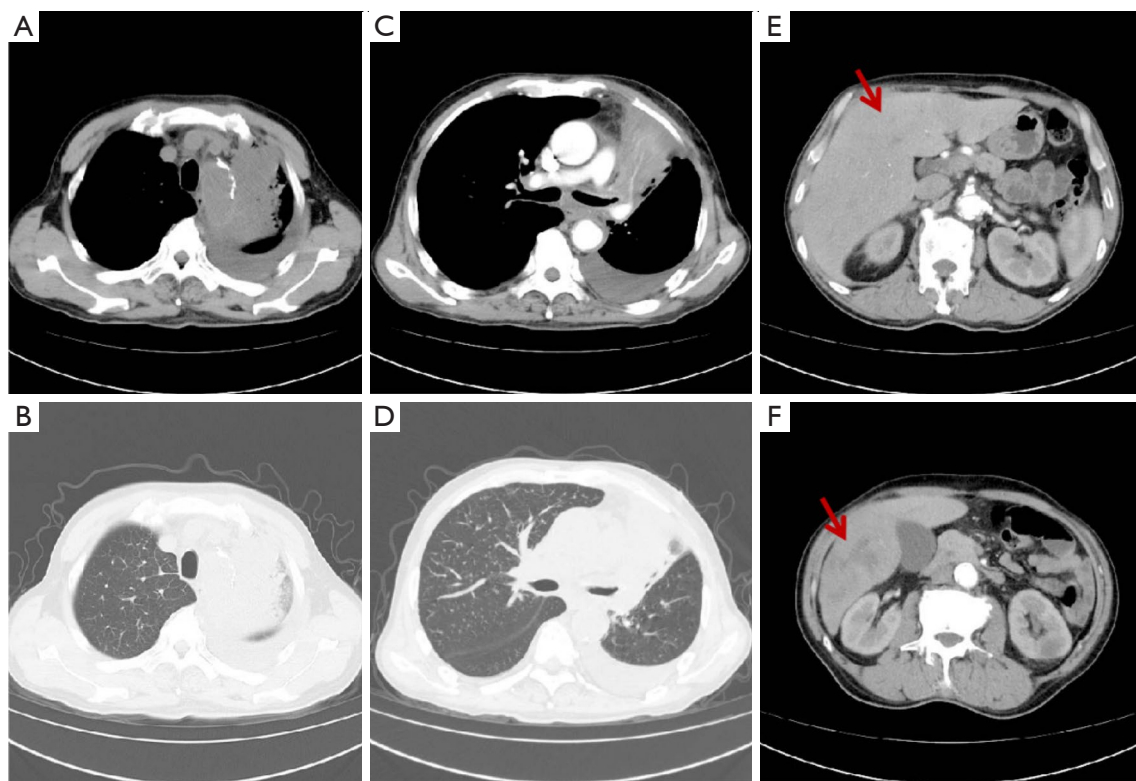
Chest CT after the pembrolizumab treatment. (A-D) The left hilar was occupied by the tumor tissue, which obstructed part of the bronchi in the left upper lobe. (E,F) Liver metastasis. The arrows indicated the liver metastatic lesions. CT, computed tomography.
